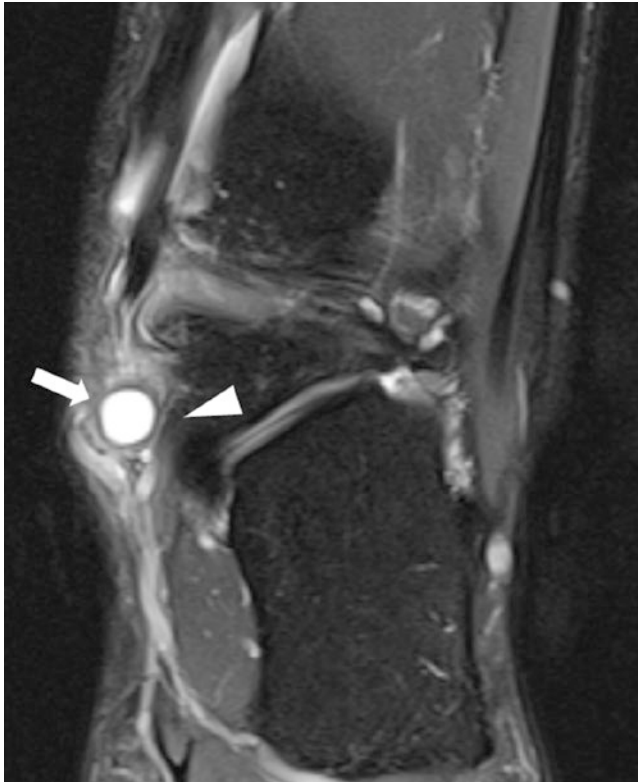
Tarsal tunnel syndrome caused by a ganglion. Coronal fat-suppressed intermediate weighted MR image of the left ankle shows cystic mass (*arrow*) with surrounding soft tissue edema entrapping the tibial nerve (*arrowhead*) in the posterior tarsal tunnel. The patient experienced typical clinical symptoms of tarsal tunnel syndrome
